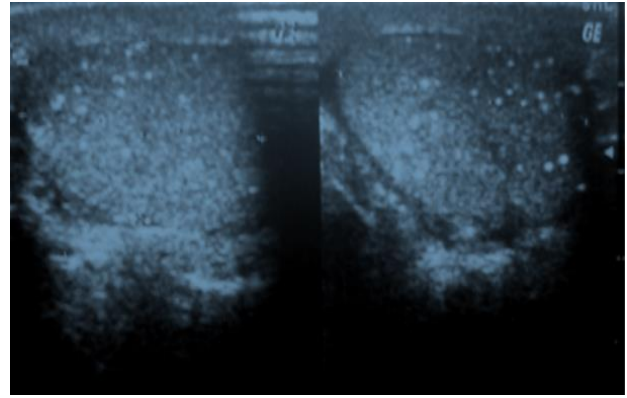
Testicular microlithiasis in scrotal sonography of the same patient.
